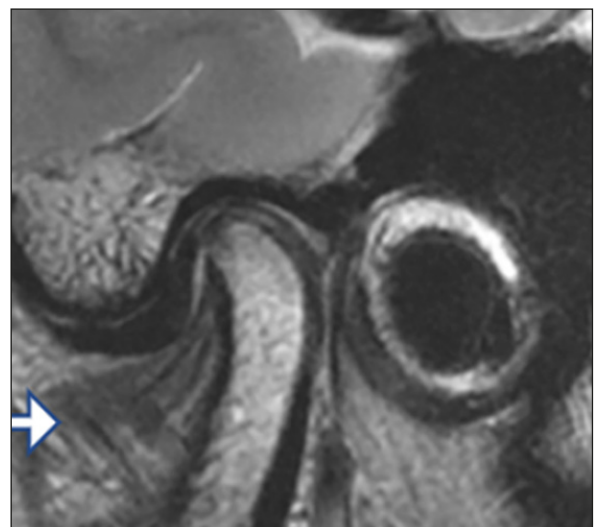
MRI showing anterior disc displacement in closed mouth position.
